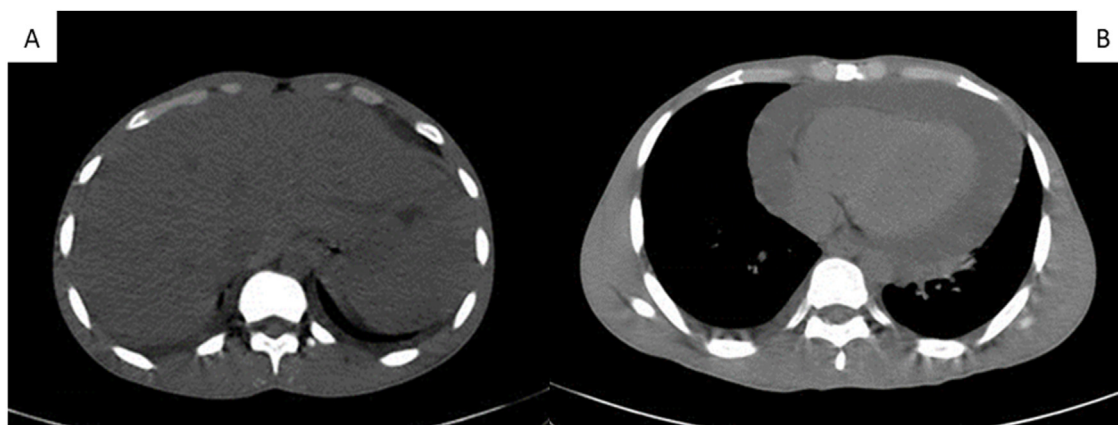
CT scan showing important hepatomegaly and perihepatic fluid (A) and abundant pericardial effusion of about 30 mm thickness (B).
